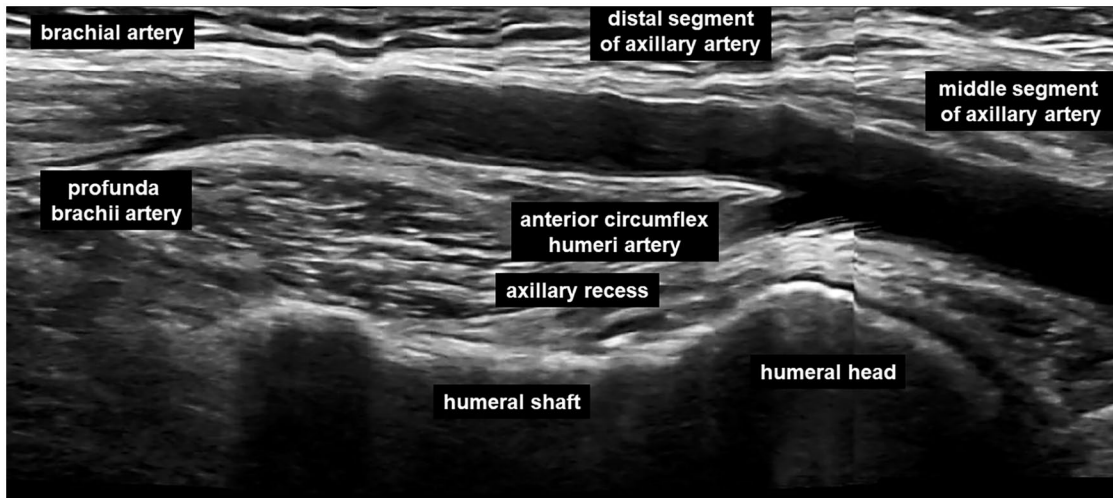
Panoramic ultrasound image displaying normal axillary artery anatomy seen from the axillary recess. The undulating walls reflect pulsations while generating the panoramic image.
